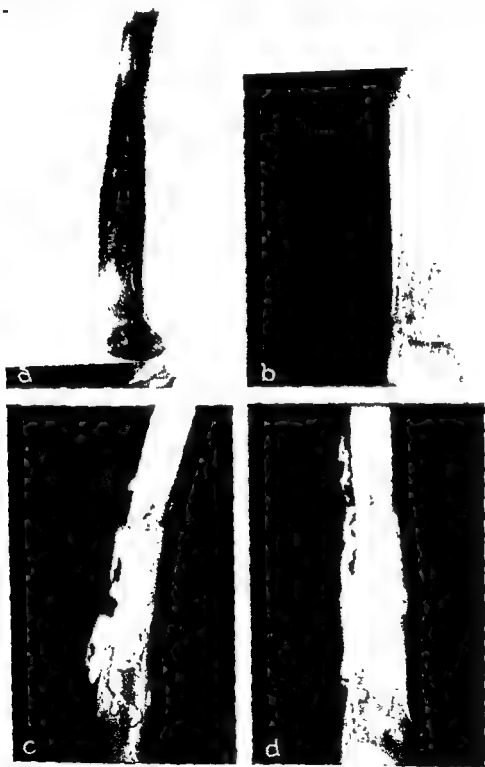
(Case E. G.). Chronic suppurative osteomyelitis of eleven years' duration. *a* and *b*, Admission roentgenograms; the oval defect in the bone is the result of previous surgery elsewhere. *c* and *d*, Extent of sinus tract is shown following injection with diodrast.
